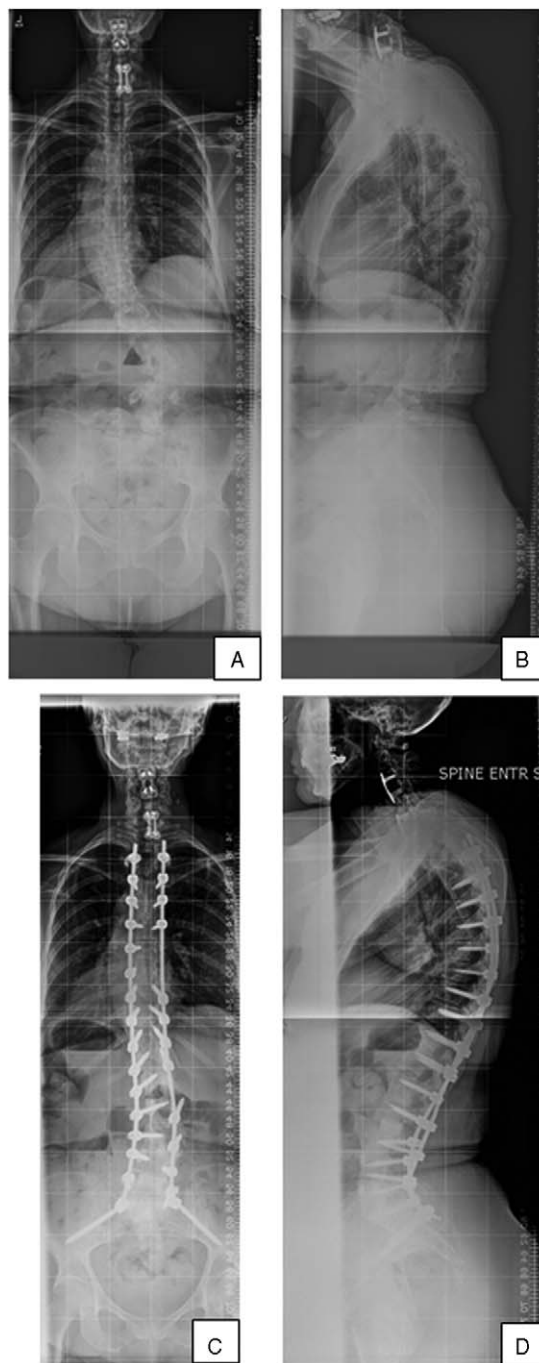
AP (A) and lateral (B) radiographs of a 69-year-old woman 2 years status postlaminectomies with bilateral complete facetectomies of L2/3-L5/S1. Small preoperative degenerative scoliosis had rapidly progressed producing recurrent radiculopathy, sagittal imbalance, and early satiety. Preoperative SVA was -2.5 cm and PI-LL was 18.3° . LSDI was 62.5, ODI was 64.4, PCS was 13.0, and SRS-22 was 2.91. AP (C) and lateral (D) radiographs taken 2 years status poststaged posterior arthrodesis from T4 to pelvis, followed by anterior discectomy and fusion from L2-S1. SVA was -3.0 cm and PI-LL was -9.4° . Final LSDI was 70, ODI was 40, PCS was 27.4, and SRS-22 was 4.15. SRS-22 Satisfaction score was also 5 (very satisfied and would elect same treatment again).
